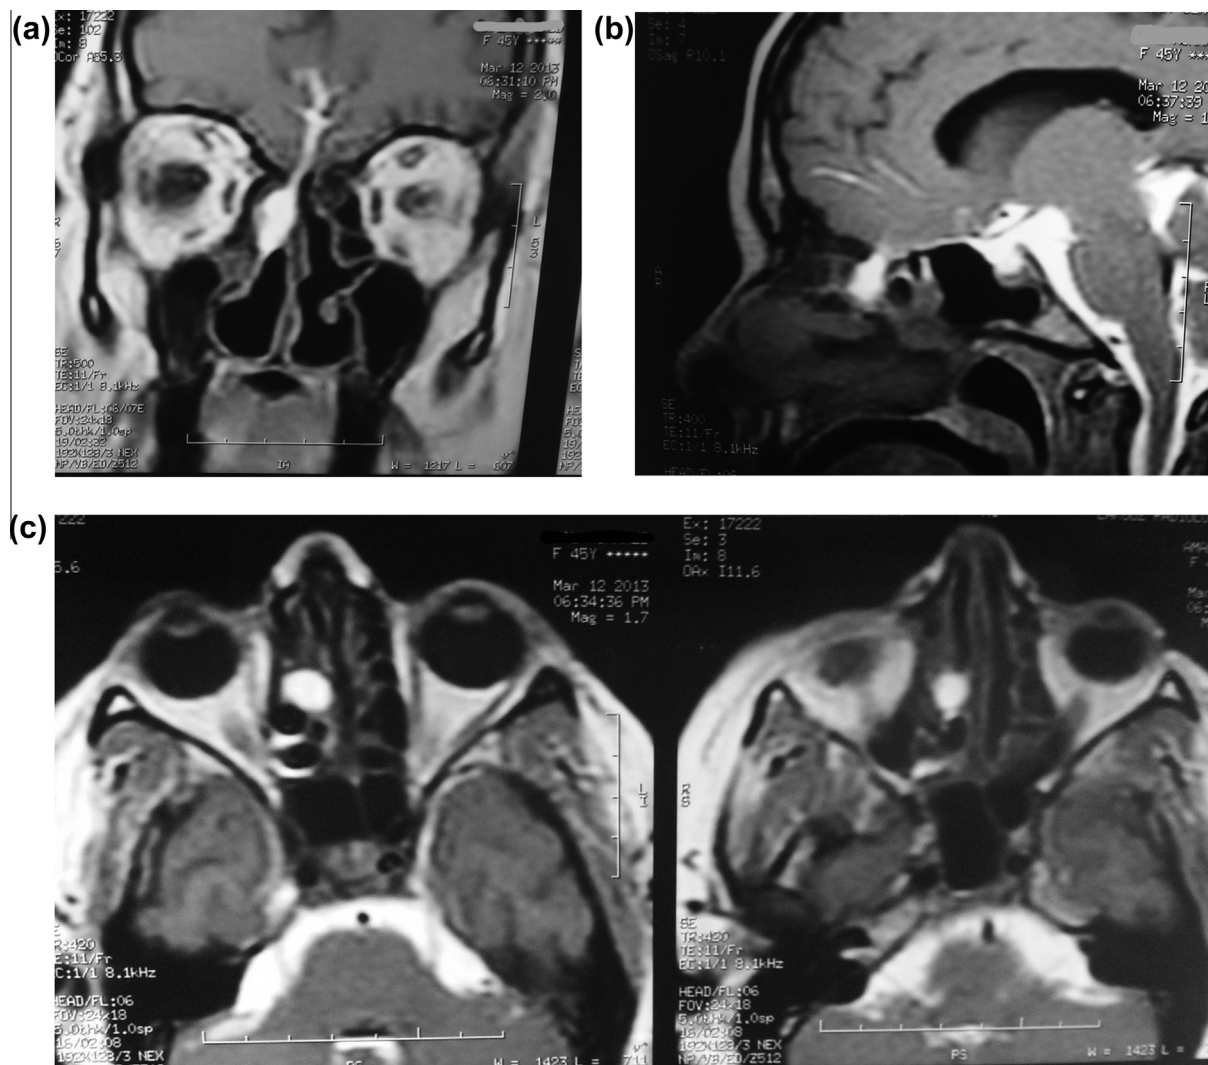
Spontaneous CSF rhinorrhea in a 45-year-old female. (a) Coronal T1-weighted intra-thecal gadolinium enhanced cisternogram shows contrast leak into the right ethmoidal air-cells through a defect in the right aspect of cribriform plate. (b, c) Right para-sagittal and axial T1-weighted intra-thecal gadolinium enhanced cisternogram reveal focal right ethmoid contrast material leakage.
